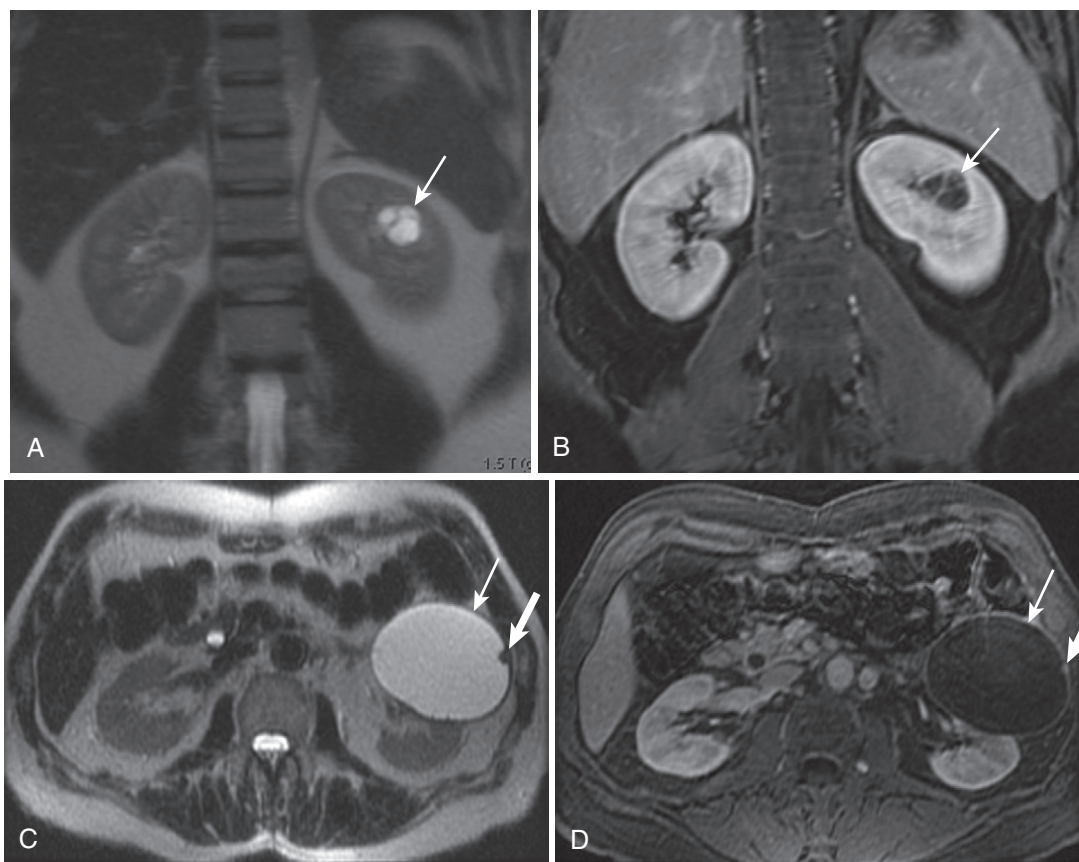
Cystic RCC. The coronal T2-weighted (A) and enhanced (B) images show a cystic lesion (*arrow*) with mildly thickened enhancing septa in a cystic clear cell RCC. Axial T2-weighted (C) and enhanced (D) images in a different patient reveal a clear cell RCC (*thin arrow*) with even less complexity—mild wall thickening and a punctate mural nodule (*thick arrow*).
